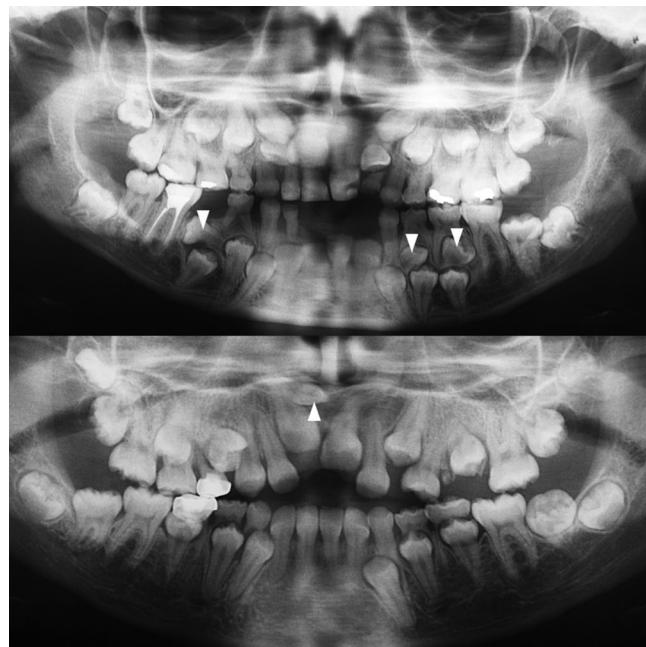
Supernumerary teeth (arrow head) in sisters (upper panel multiple mandibular premolars are visible on the panoramic radiograph; lower panel the supernumerary tooth is seen in the upper incisor area)
